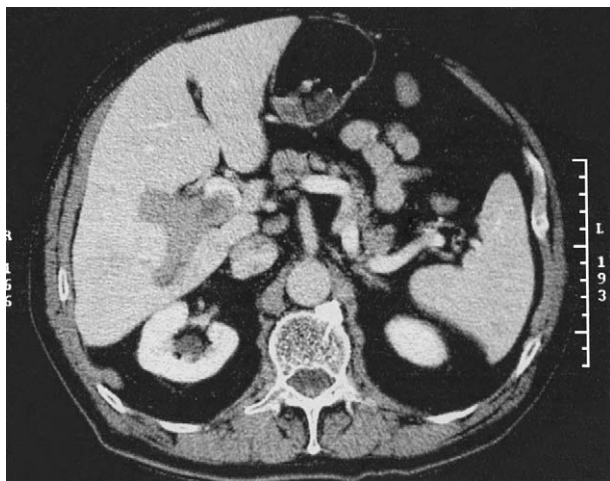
CT scan showing solitary HCC located in segment VI, with tumor thrombus in the right portal vein almost completely obstructing the portal bifurcation.
